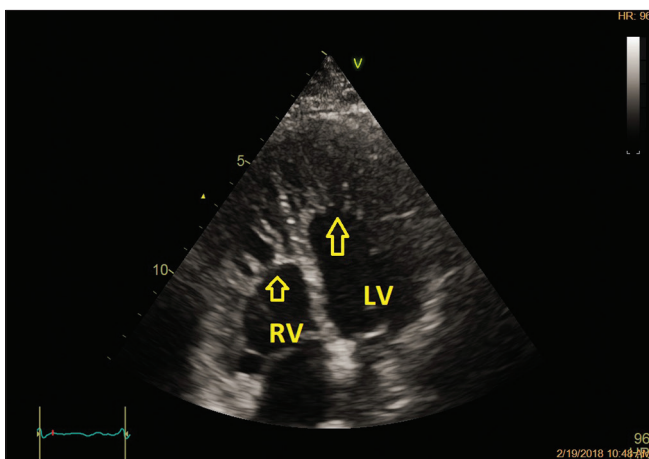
Transthoracic echocardiography in the four-chamber view, demonstrating hypertrabeculation with deep recesses. LV, left ventricle; RV, right ventricle
